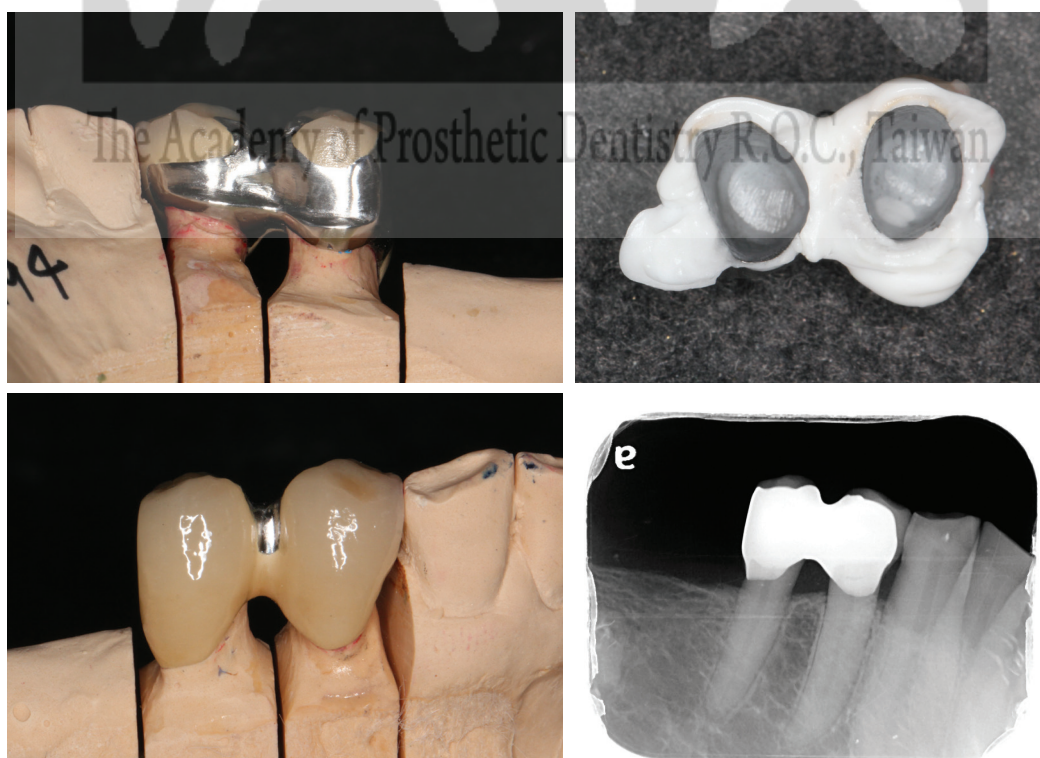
delivery of 44-45 and periapical film after cementation
